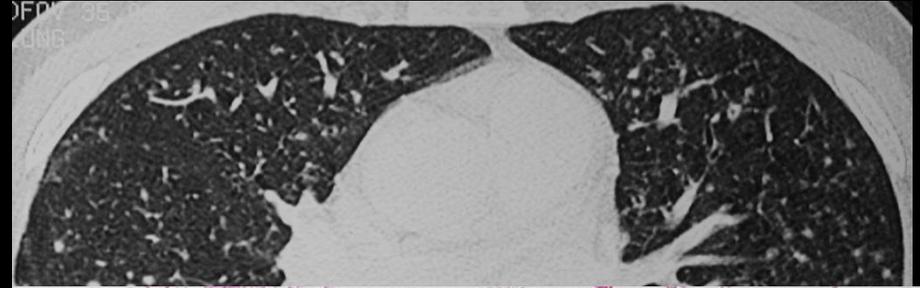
Abbot Radiographics 2004
